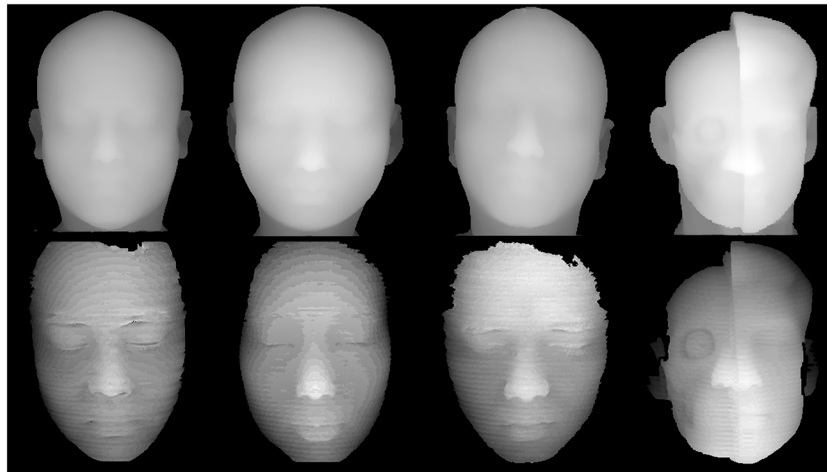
The first three images of the upper row are MRI-segmented faces of volunteers, and the fourth image of the upper row is the CT-segmented face of the model. The bottom images are the corresponding reconstructed faces
